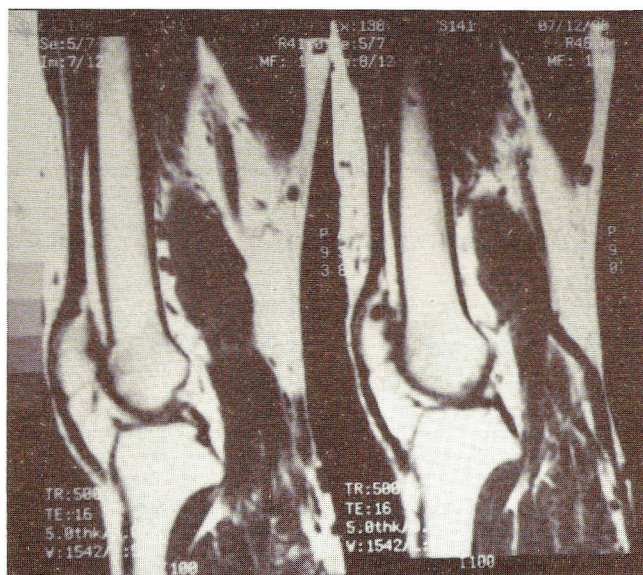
Preoperative magnetic resonance imaging scans confirming the previous findings
